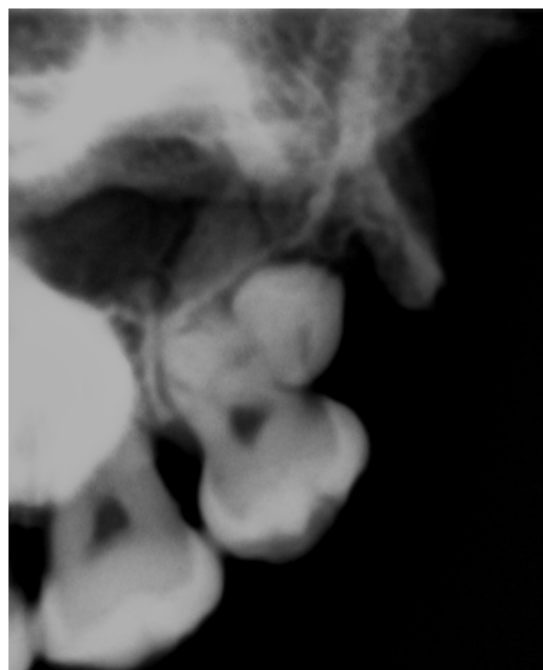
X-ray photo of the abnormal third molar in left site of the alveolar arch. Concrescence of the two roots behind the distal surface of the third molar's crown.
